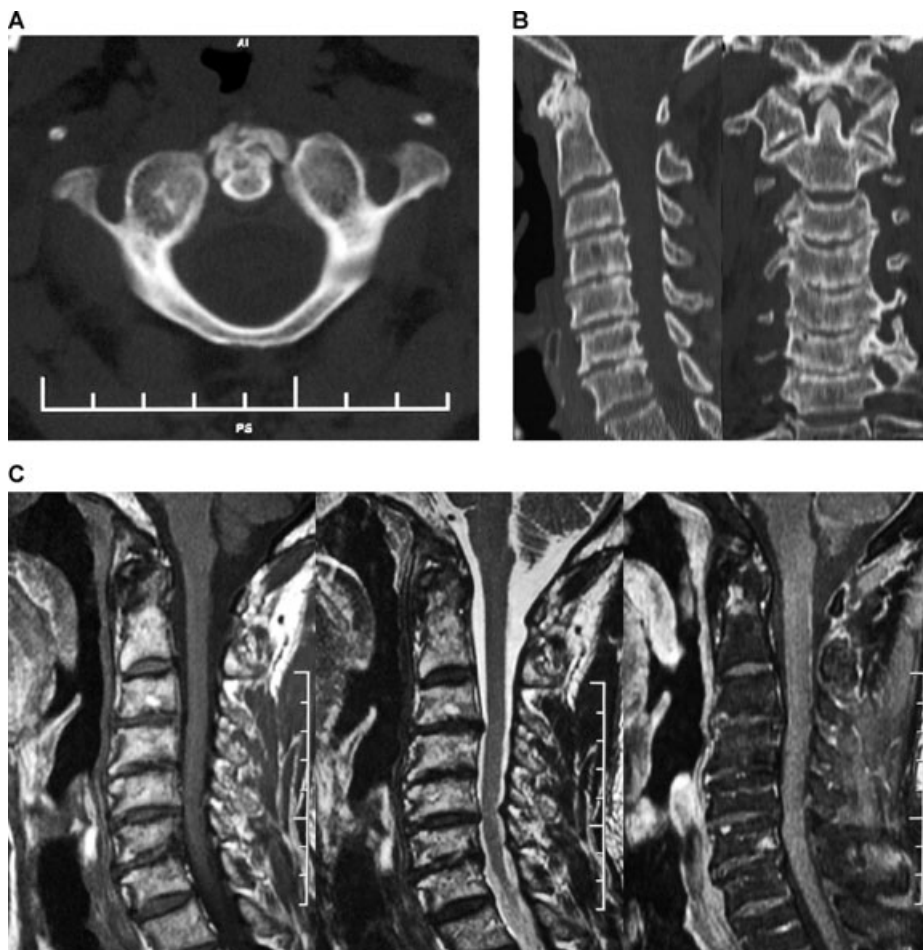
Axial CT section at the level of the atlanto-axial articulation (A) show degenerative articular disease, odontoid cysts and erosions, and periodontoid calcifications. Reformatted images (B), besides showing in a more elegant way the same findings of the axial slices, reveal advanced cervical spondylosis; notice the crown-like calcifications in the soft tissues around the dens and in the periodontoid ligaments. (C) MR sections of the same patient—sagittal T1-WI (left), T2-WI (center), and post-gadolinium T1-WI with fat suppression (right)—show that although the calcifications and the bone erosions are clearly more evident on CT scans, MR demonstrates post-gadolinium enhancement (seen on the right image), indicative of inflammatory activity.
